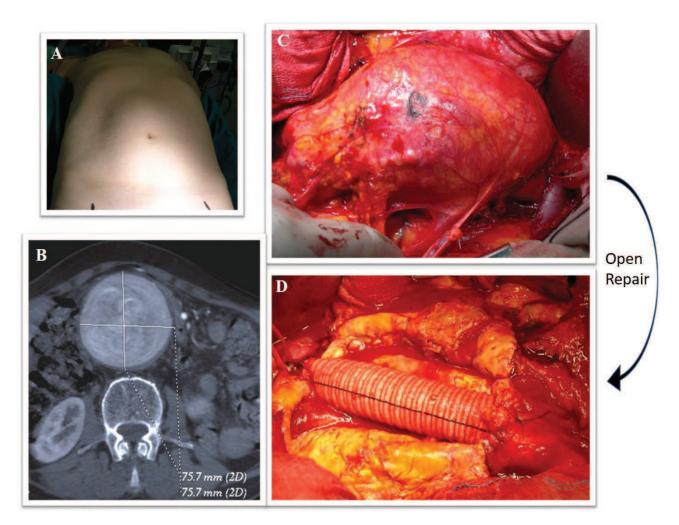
Open surgical repair (A) Abdomen of AAA patient (B) Abdominal CT showing aorta dilatation C) Aneurysm sac during surgical open repair D) Abdominal aortic graft in Dacron. Courtesy of Dr. Casella
